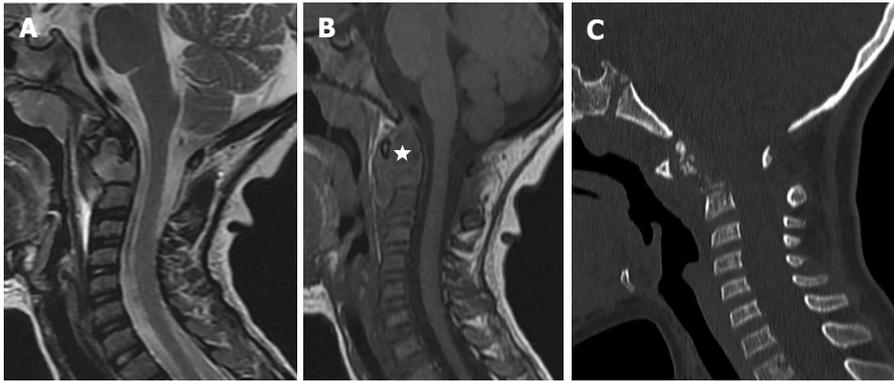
Initial cervical imaging: Sagittal FSET2 (A), SET1 magnetic resonance images (B) and Sagittal thin slice CT image (C). Infiltrative mass involving the dens of C2 hypointense on T1 and hyperintense on T2 sequence, extending to the surrounding soft tissues (star) leading to an increase in C1-C2 space. No compression of the spinal cervical cord. No signal abnormality nor rupture of the posterior longitudinal ligament spine. Complement CT showed fragmented dens with important C1-C2 dislocation.
